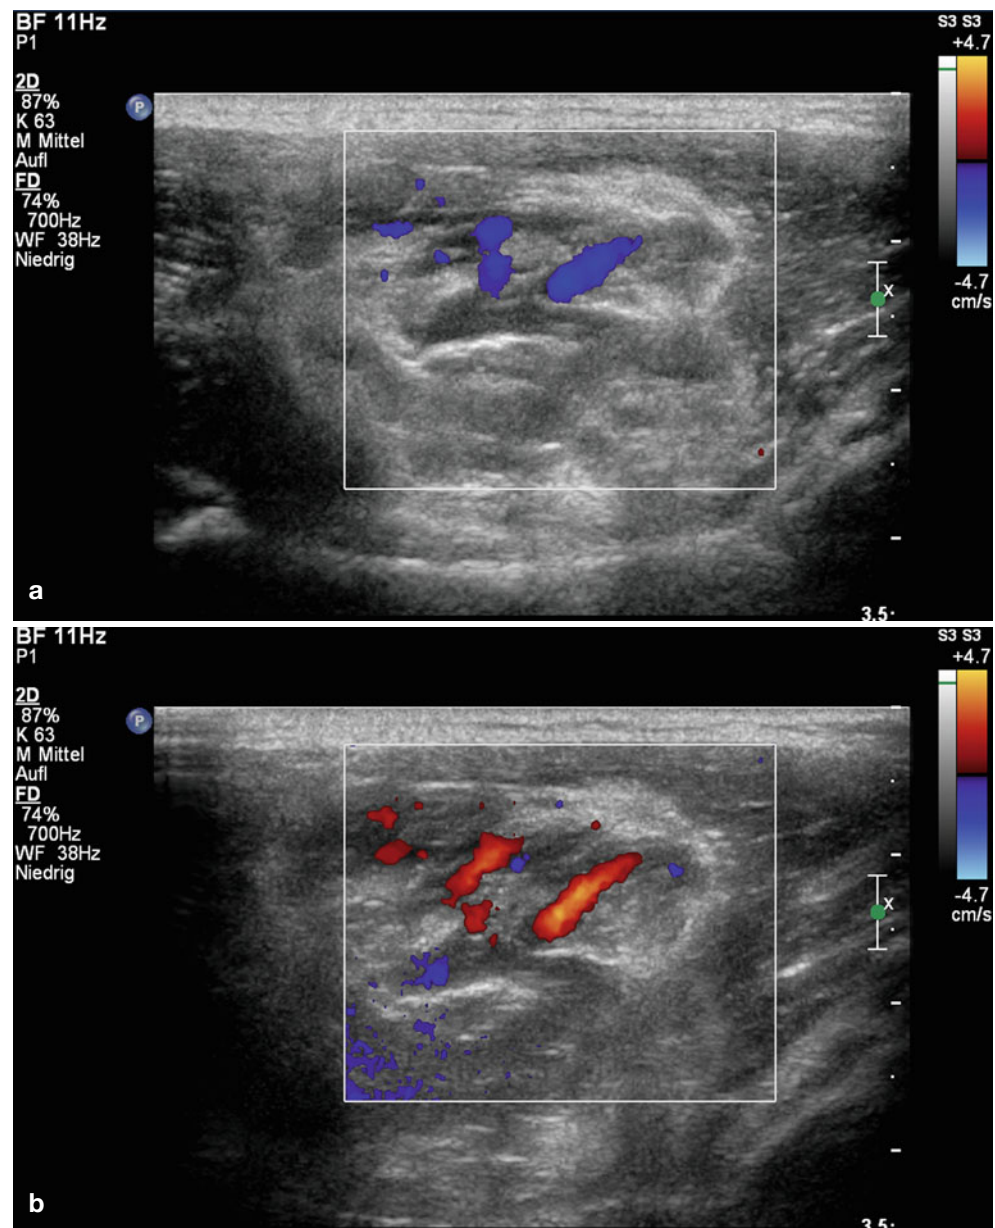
(a, b) Compression ultrasound in a patient with low flow venous malformation: note color change from red to blue during the compression test confirming bidirectional venous flow
